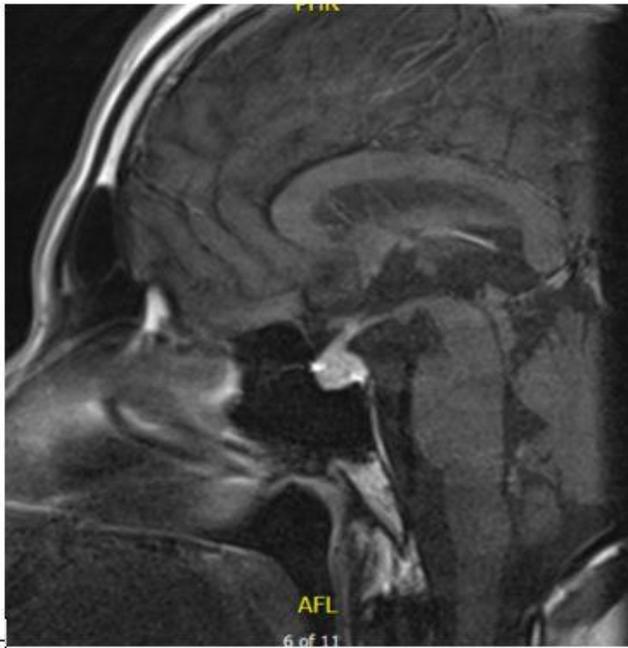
MRI pituitary demonstrating Mildly enlarged pituitary gland with thickened but midline pituitary stalk suggestive of lymphocytic hypophysitis
